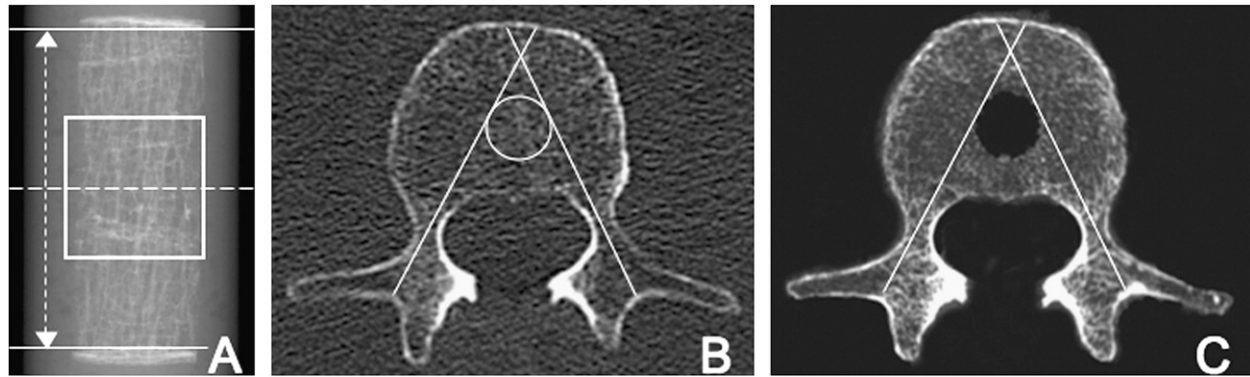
(A) Lateral μ CT scout view of a representative core. The central VOI (10-mm white outlined box) was defined by (i) measuring the distance between the upper and lower margins of where the trabecular bone network starts (solid white lines) and (ii) identifying the central slice (dotted line) using the following formula: $(\text{upper}_{\text{margin}} - \text{lower}_{\text{margin}})/2$. The scan (625 axial slices, 10 mm) was set to start 5 mm above the central slice. An axial MDCT section of the intact vertebral body acquired with protocol B is shown in B. The matching HR-pQCT section of the vertebral body with core defect after reformation is depicted in C. Alignment of reference lines at reproducible anatomical landmarks is used to locate and define the volume of interest within the MDCT image.
